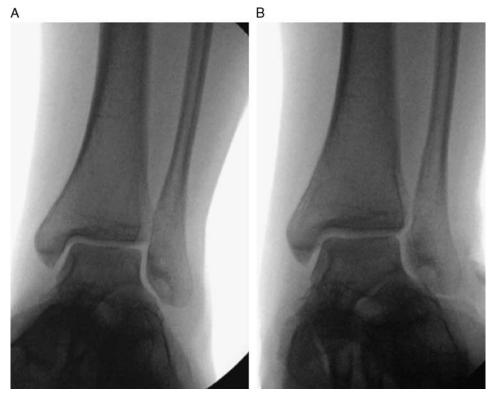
Mortise x-rays of the ankle. A, Preoperative mortise ankle x-ray. B, Valgus stress view. Widening in medial clear space is noted.
